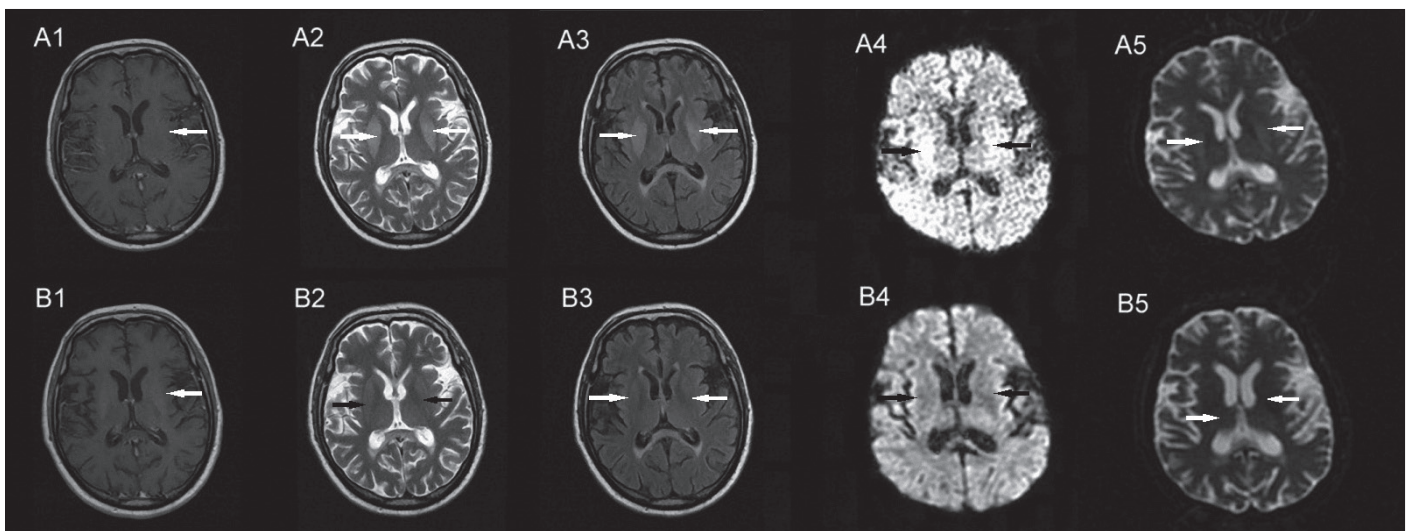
1. T1-weighted image, 2. T2-weighted image, 3. Fluid-attenuated inversion recovery (FLAIR) image, 4. Diffusion-weighted image, 5. Apparent diffusion coefficient (ADC) map. Initial brain MR imaging demonstrating bilateral basal ganglia lesions (A1-5). Intense edema is seen in the basal ganglia indicated by arrows. These areas show hyperintensities on T2- and diffusion-weighted, and FLAIR images, while the same lesions show isointensity on the T1-weighted image. The corresponding areas have slightly increased signal intensities on the ADC map. No significant changes were observed in the other areas of the brain except minimal senile atrophy. Follow-up MR imaging (B 1-5) performed 3 months after onset shows decreased signal change and size of the focal edema in the basal ganglia compared with the previous study. Discrete symmetrical signal changes over bilateral globus pallidus structures are noted (arrows; hyperintensities on T2- weighted image and ADC map, and isointensities on T1-weighted, and FLAIR images).
